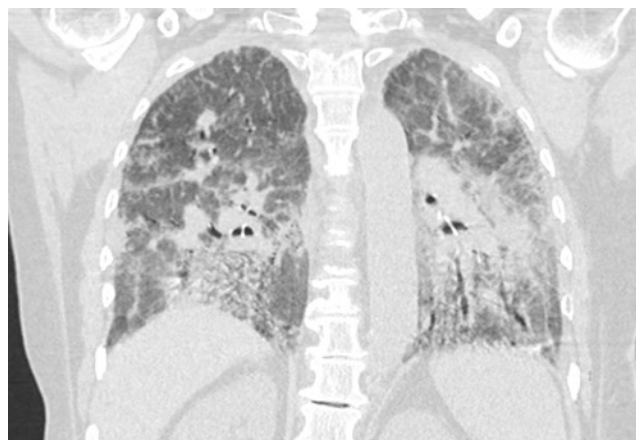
HRCT showing diffuse bilateral diffuse coarse ground-glass opacities with thickened irregular interlobular septa, bronchiectasis and bronchiolectasis, architectural distortion, and inconspicuous honeycombing, consistent with hypersensitivity pneumonitis
